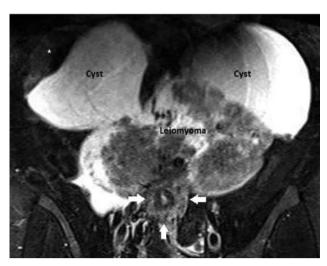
MRI image of the mass. A coronal T2-weighted fatsaturated image showing a well-defined semi-solid pelvic mass extending into both uterine adnexal areas. The mass contains obvious two-sided cystic areas, which present as hyperintense regions on T2-weighted images. A likely continuity exists between the mass and the uterine fundus. A solid area within the wall of the right cyst is apparent in the right cystic lobule of the mass (asterisk). A minimum amount of free fluid is noted in the pelvis (arrows show the uterus).
